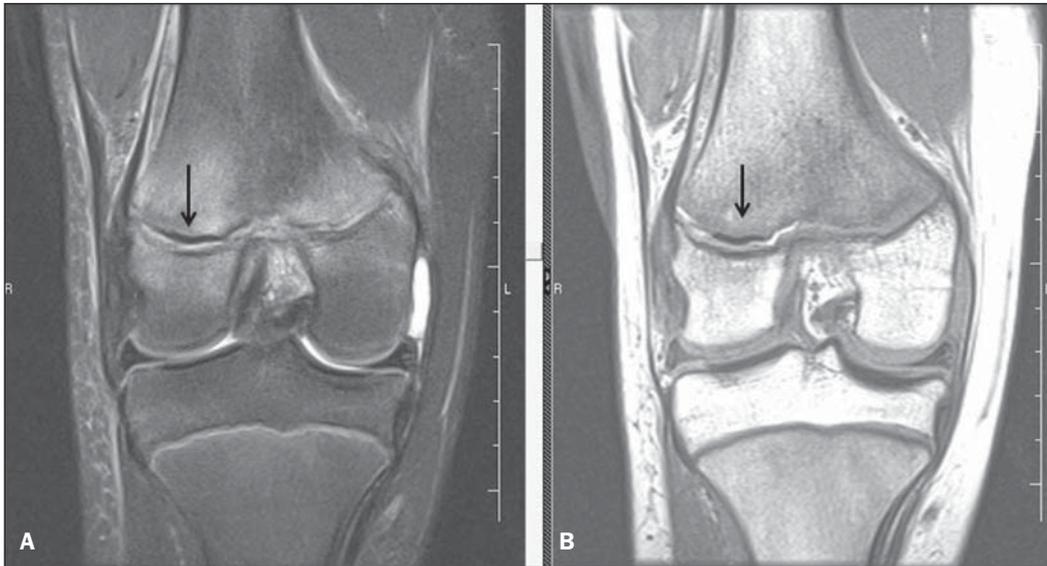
Magnetic resonance imaging, sagittal T2-weighted image with fat saturation (A) and T1-weighted image (B). Change in signal intensity along the lateral distal femoral epiphyseal plate, with interposition of a hypointense structure compatible with periosteal fragment.
